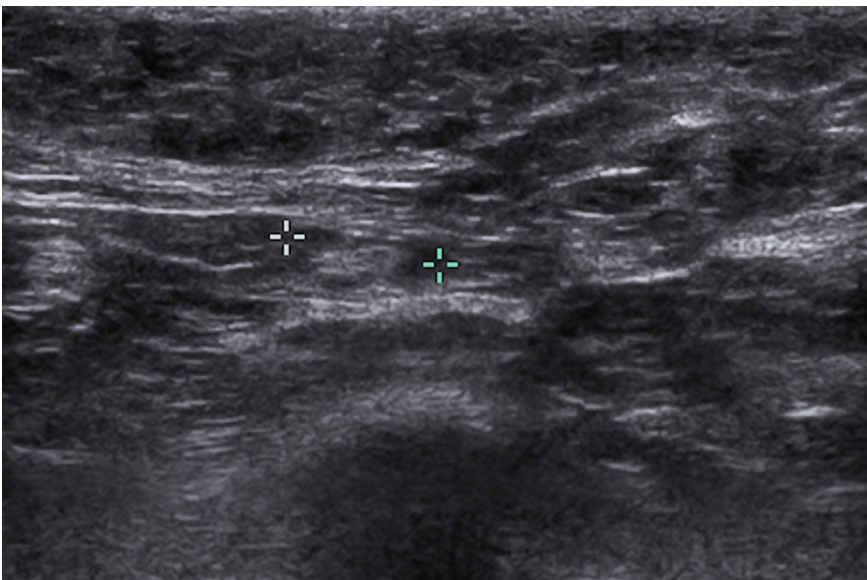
Conventional grey-scale ultrasound image of the SLN (bracketed) visualised in figure 1
